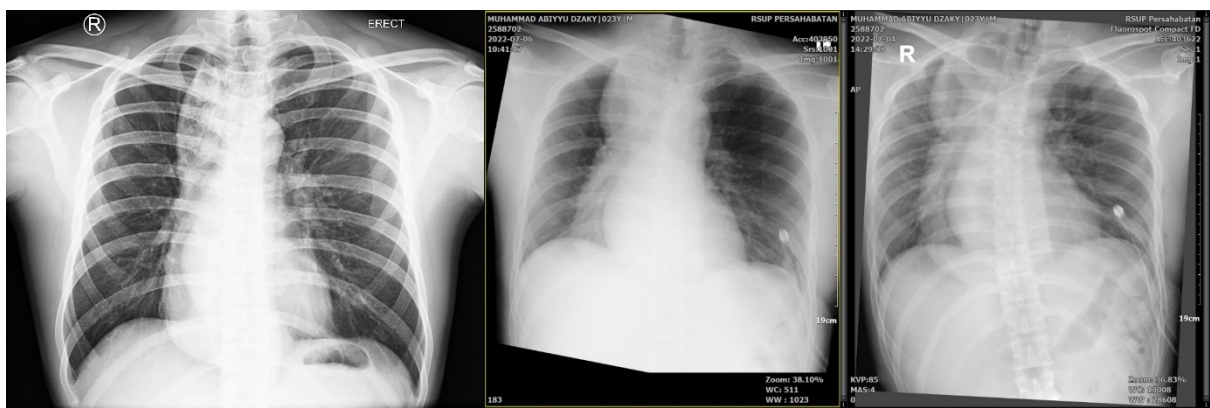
Preoperative chest x-ray (left); POD 0 (middle), and POD 3 (right)
